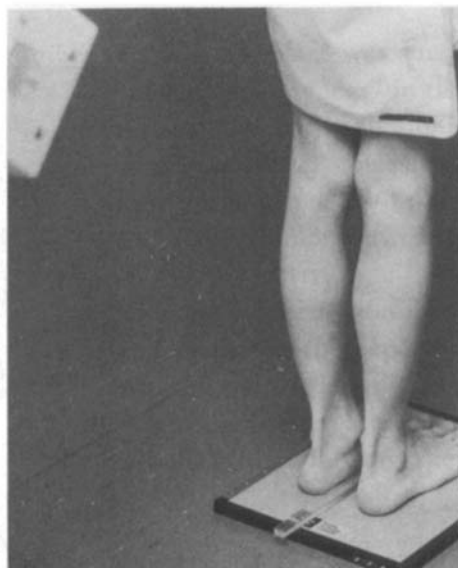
Set-up for the suroplantar radiograph.
